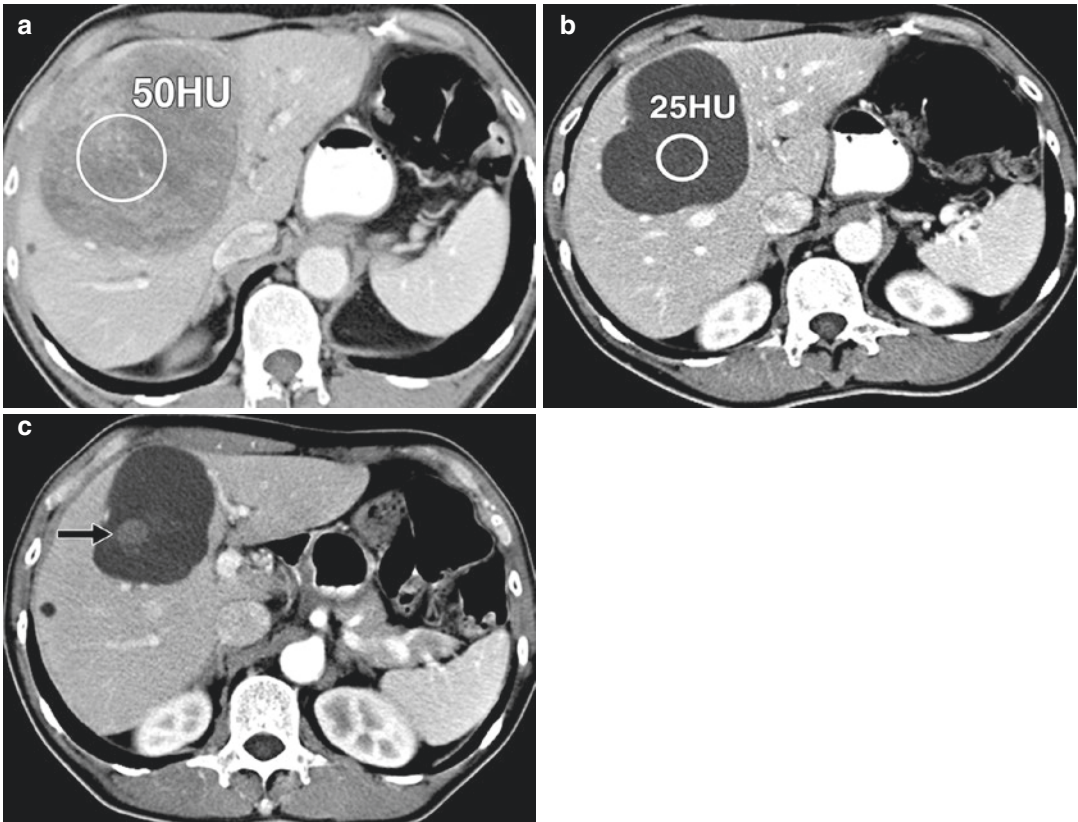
A 58-year-old man with advanced gastrointestinal stromal tumor with liver metastasis, treated with imatinib mesylate. (Reprinted with permission from *AJR Am J Roentgenol.* 2012;198: 737–745). (a) Baseline contrast-enhanced CT of abdomen before therapy shows heterogeneously enhancing mass in liver representing metastasis, measuring 10 cm in longest diameter and 50 HU in CT attenuation (circle). (b) Follow-up CT scan obtained 8 weeks after initiation of imatinib mesylate therapy shows significant decrease in CT attenuation of tumor (circle; 25 HU), meeting criteria for response by Choi
